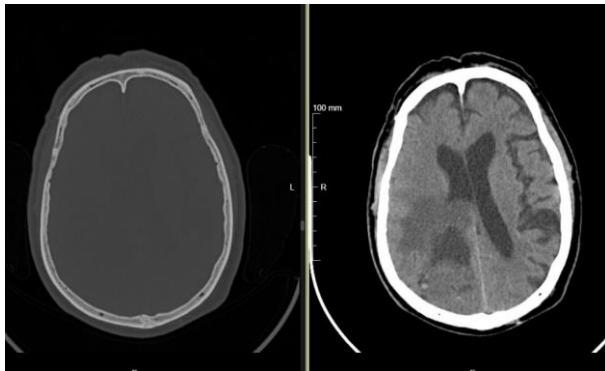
Emergency CT Scan revealing cystic parieto-occipital mass.
